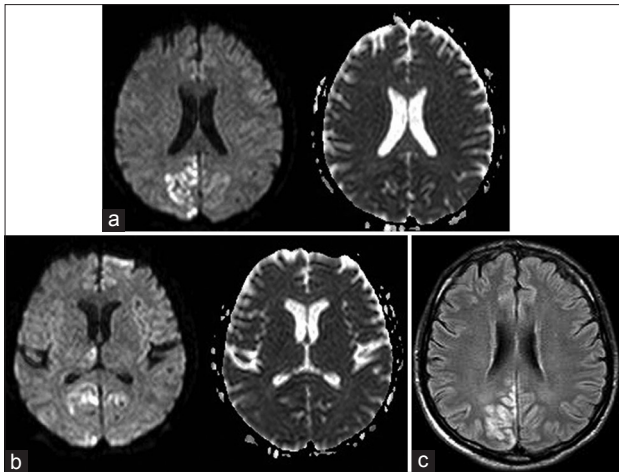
(a and b) Magnetic resonance imaging: diffusion-weighted imaging (on the left) and corresponding apparent diffusion coefficient map (on the right). Hyperintensity in diffusion-weighted imaging and hypointensity in apparent diffusion coefficient map can be seen in the occipito-parietal cortex bilaterally, with a significant larger extension on the right side (a) and also in the right medial thalamus (b). (c) Fluid-attenuated inversion recovery magnetic resonance imaging confirms asymmetrical, mainly on the right side, ischemic lesion showing bilaterally high signal intensity areas in the occipito-parietal cortex
